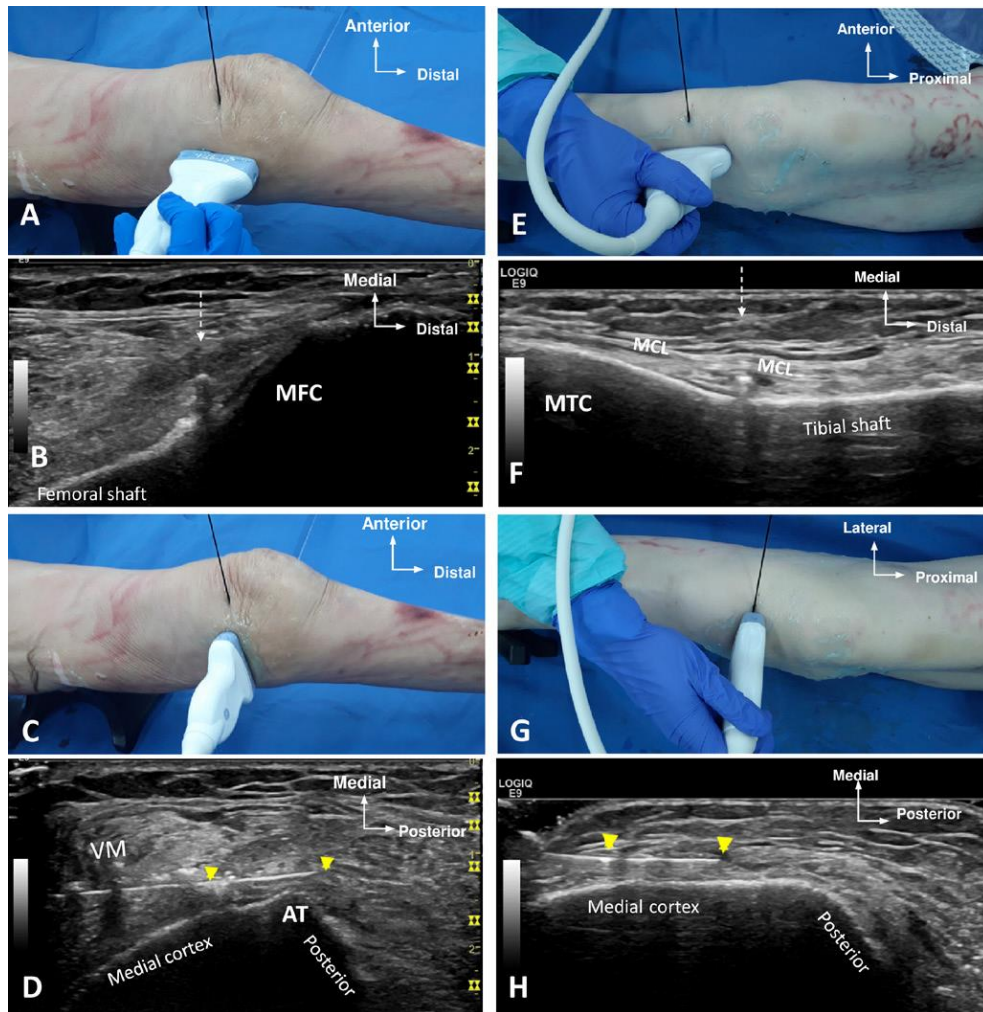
Cannula placement and ultrasound landmarks for SMGN and IMGN in cadaveric knee. (A,B) Coronal plane: target point for SMGN. (C,D) Axial plane: final position of the RF cannula for SMGN (with the active tip highlighted with two yellow arrowheads). (E,F) Coronal plane: target point for IMGN. (G,H) Axial plane: target point for IMGN. Vertical dashed arrows indicate target level on coronal view; yellow arrowheads indicate limits of the active tip.
